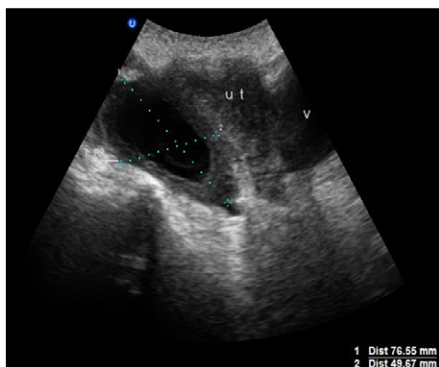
Ultrasound showing the decrease in the size of the hematoma, after one month (76.55 mm).
